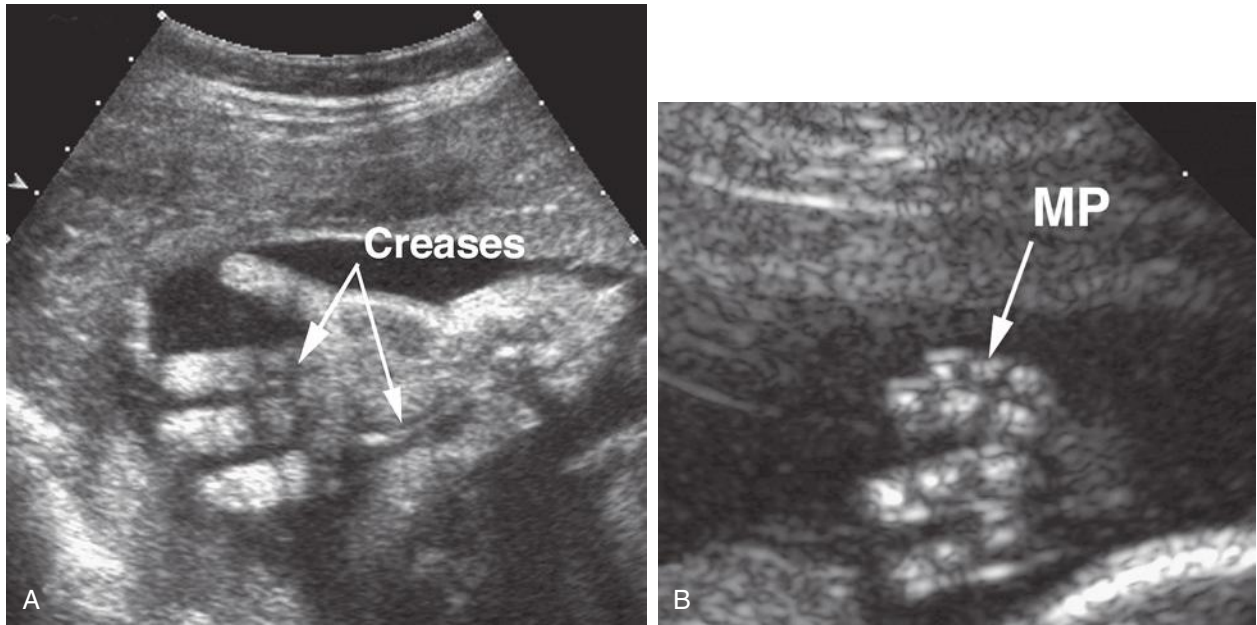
A, Coronal sonogram of the fetal hand demonstrating the soft tissues of the fingers and palm. Creases at the interphalangeal joints and palmar creases are seen. B, Coronal sonogram of the hand demonstrating some of the bony detail of the developing phalanges. MP, middle phalanx.
